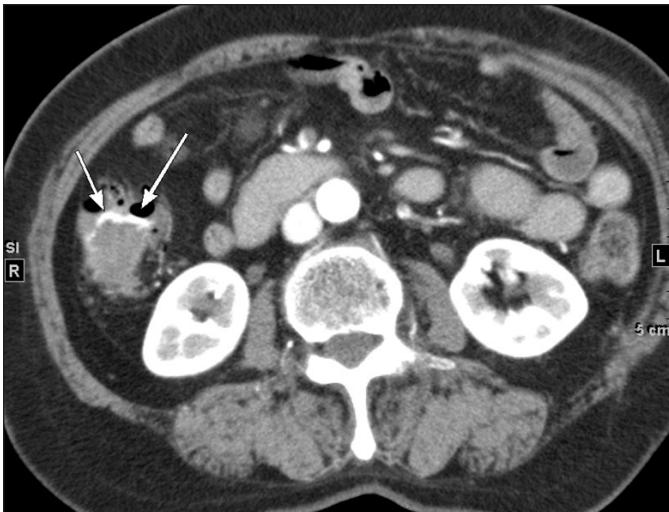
Enhanced CT demonstrated extravasation in the ascending colon.
